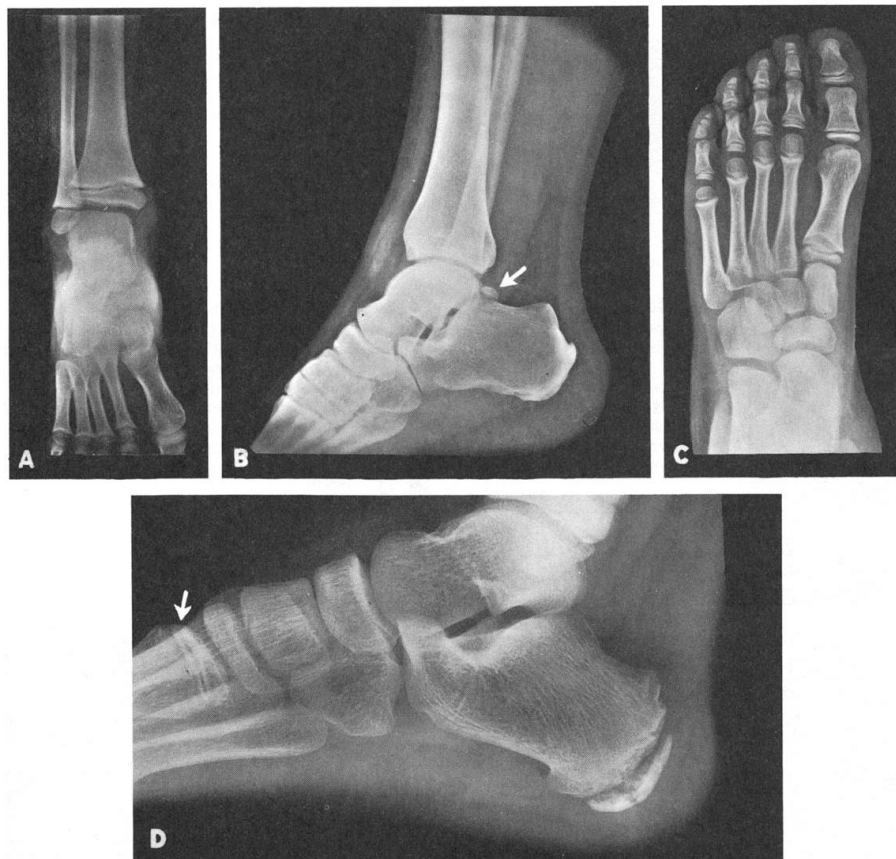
Child and adult X-ray of foot and ankle. A, Child's ankle. Note the epiphyses for the inferior ends of the fibula and tibia. The epiphysial line of the fibula is in line with the ankle joint. B, lateral view of an adult ankle. C, Child's foot. Note the epiphyses for the metatarsals and phalanges. D, lateral view of child's foot. Adapted from Warwick and Williams (1989)³⁶⁰
